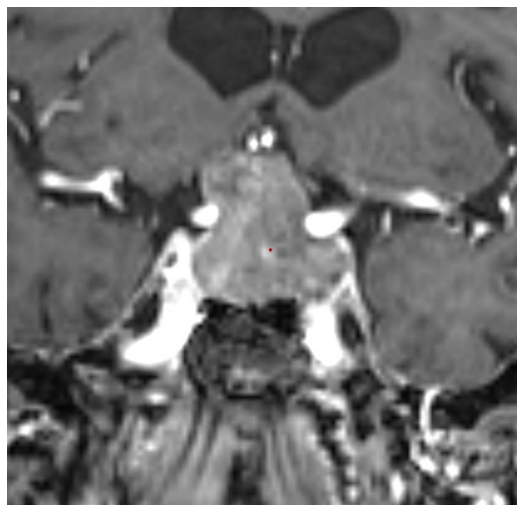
Assessing the Knosp Grade with a midsella Coronal T1-weighted contrast-enhanced MRI-scan using the Medtronic S8 Navigation system (Medtronic, Colorado, USA).
